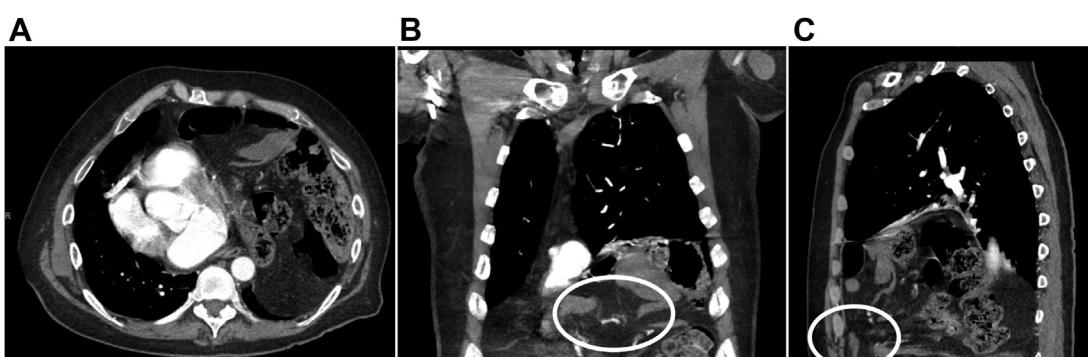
CT imaging of gigantic complex left-sided Morgagni hernia containing small intestine, large intestine, and portion of the pancreas and spleen. (A) Axial, (B) Coronal, (C) Sagittal. White circle depicts a large anterior diaphragmatic defect.
